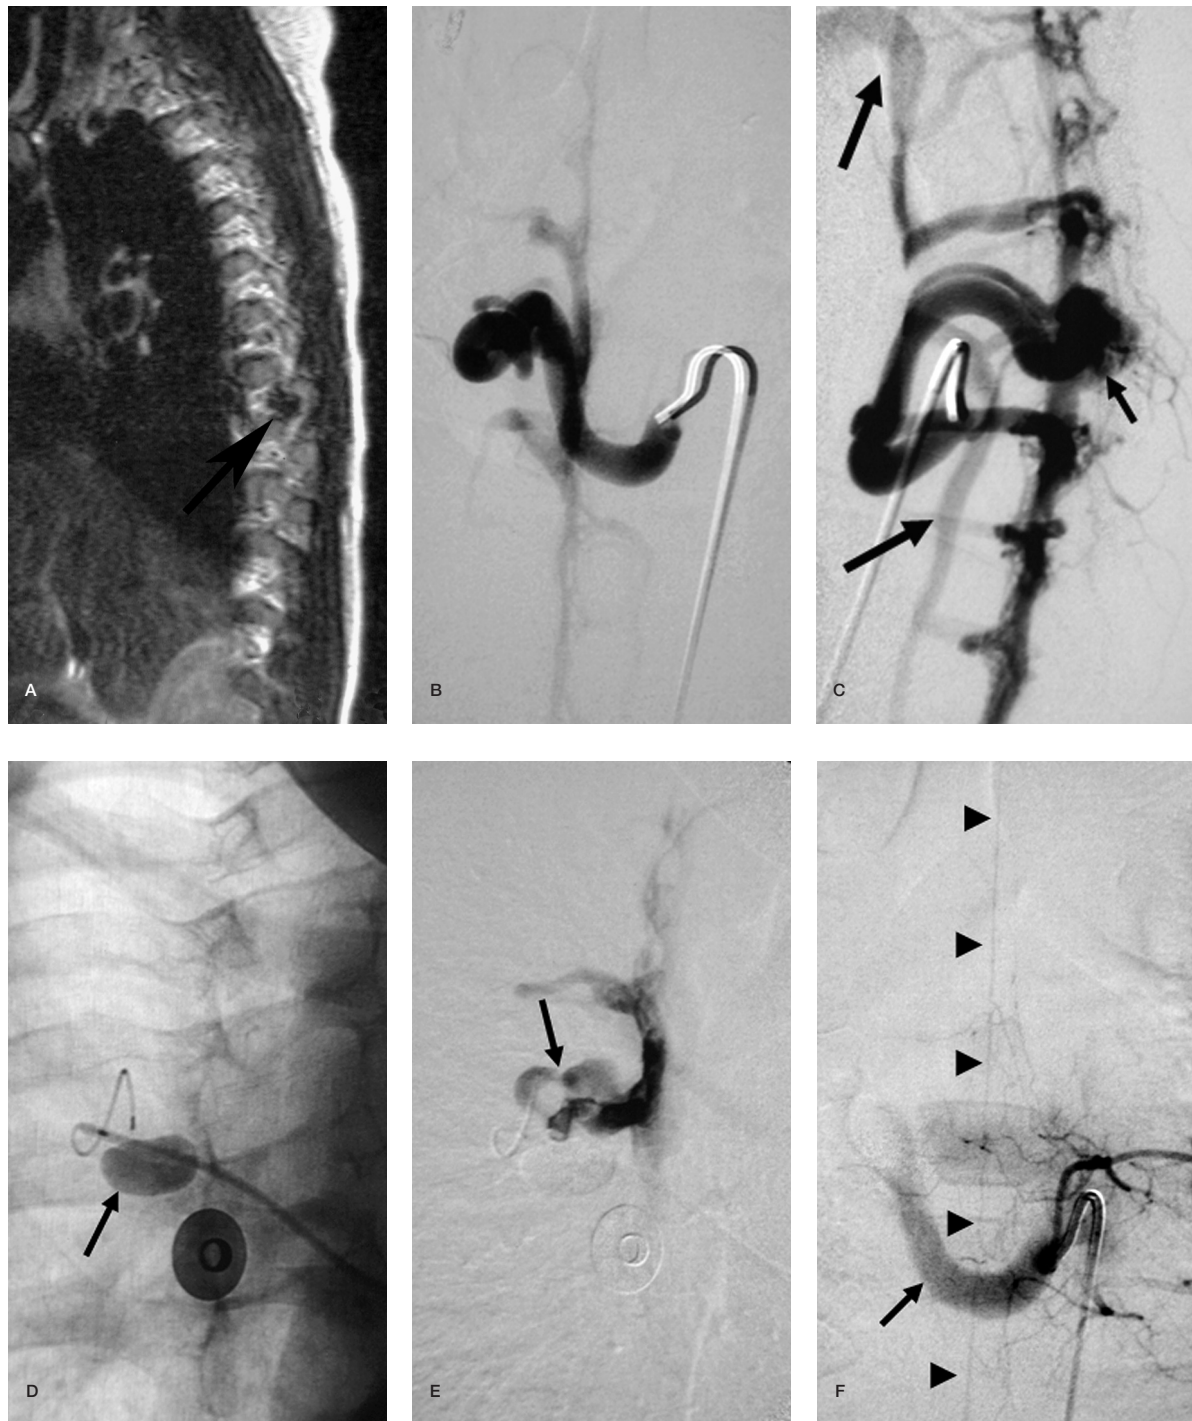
A) Lateral T1-weighted MRI of thoracic spine shows a low signal intensity lesion in a paraspinal location adjacent to a nerve root (arrow). B) AP view of right T7 intercostal artery angiogram demonstrating a high flow single hole fistula along the nerve root draining to the epidural venous plexus. C) Lateral view of right T7 intercostal artery angiogram demonstrating a single hole fistula along the nerve root (arrow) draining to the epidural venous plexus. There is opacification of venous drainage to azygos hemiazygos system (large arrows). D,E) Non-subtracted (D) and subtracted (E) superselective angiogram from the microcatheter placed near the fistula site (arrow in E) through the double lumen balloon catheter which was inflated to decrease the flow through the fistula (arrow in D). F) Left T7 intercostal artery angiogram after embolization demonstrating preservation of the anterior spinal artery (arrow heads). There is stagnation of contrast in the proximal right T7 intercostal artery which previously supplied the fistula (arrow).
